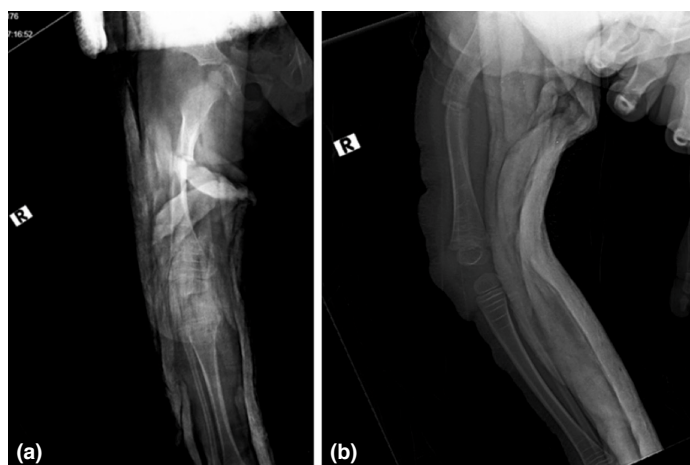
X-ray images of the patient 2 years ago after pelvipedal brace. (a) Right femur ap view. (b) Right femur lateral view.
